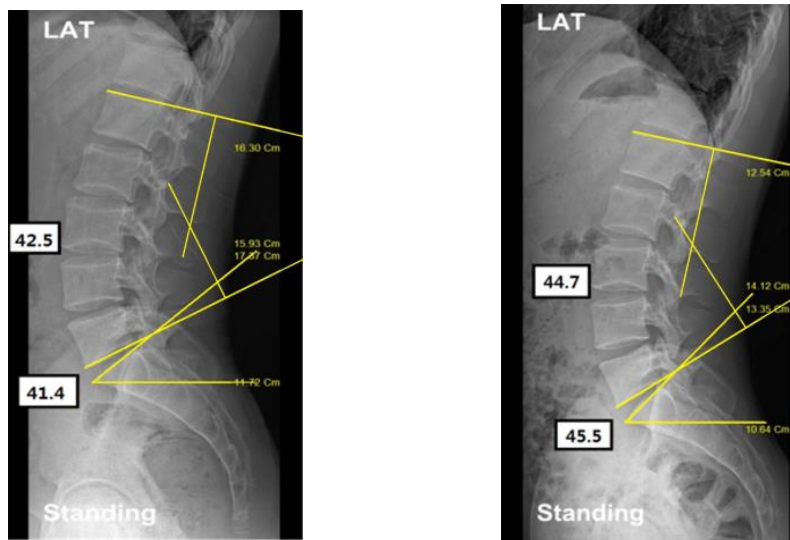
Thermography comparative analysis before and after x-ray of spine displacement of participant 11.
